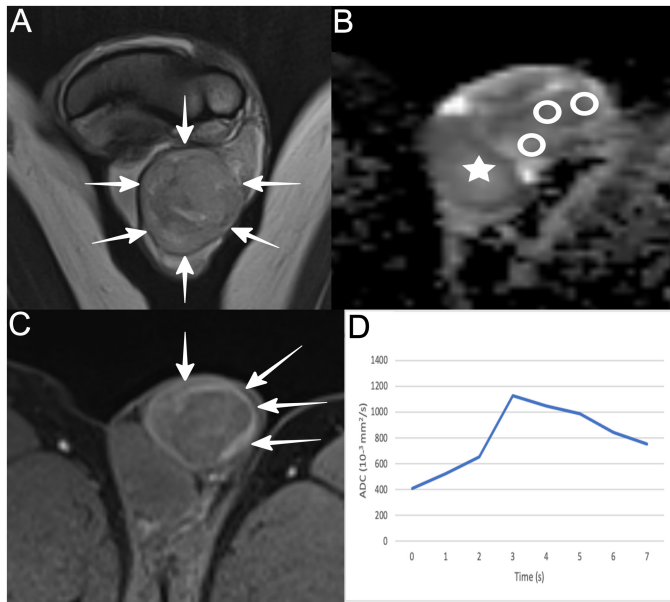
Left mixed-NSGCT (postpubertal type yolk sac, embryonal carcinoma, and postpubertal type teratoma) in a 31-year-old man. (A) Coronal T2-weighted image shows large heterogeneous hypointense left testicular mass (arrows). (B) Axial ADC map ($b=800 \text{ s/mm}^2$) shows the tumor appears slightly hypointense compared to the contralateral testis (star) and has mild restricted diffusion. The mean ADC values (circular ROIs) of the tumor were $1.07 \times 10^{-3} \text{ mm}^2/\text{s}$. (C) Axial DCE image in the early phase (180 seconds) shows nonhomogeneous circumferential tumor enhancement (arrows). Septal enhancement is absent. (D) TSI curve is typical of malignancy (type III). ADC, apparent diffusion coefficient; DCE, dynamic contrast-enhanced images; NSGCT, non-seminomatous germ cell tumor; ROI, region of interest; TSI, time signal intensity.
